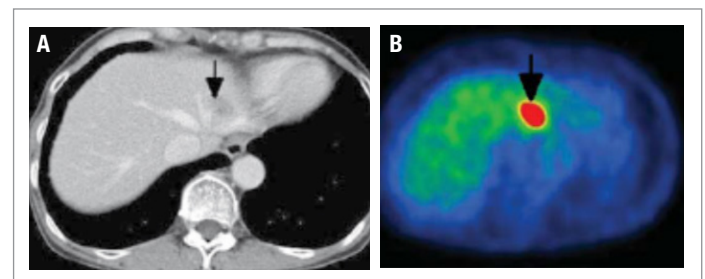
CT of the liver (A) and FDG PET-CT (B) showing uptake of FDG by the malignant liver mass.
